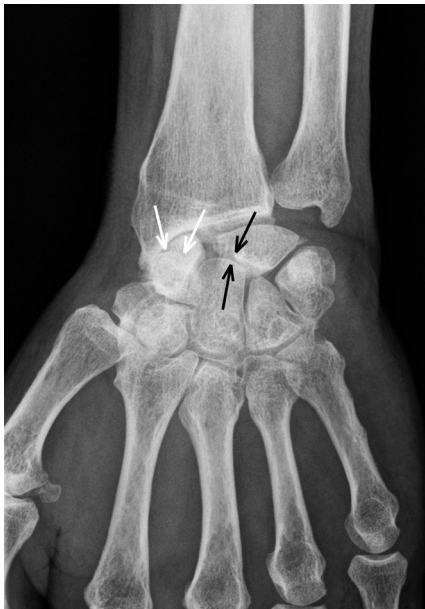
AP X-ray image of the right wrist: scapholunate diastasis with flexion of the scaphoid ('cortical ring sign' of the scaphoid tubercle visible – white arrows), severe radioscaphoid narrowing and narrowing of the lunocapitate joint space (black arrows).
